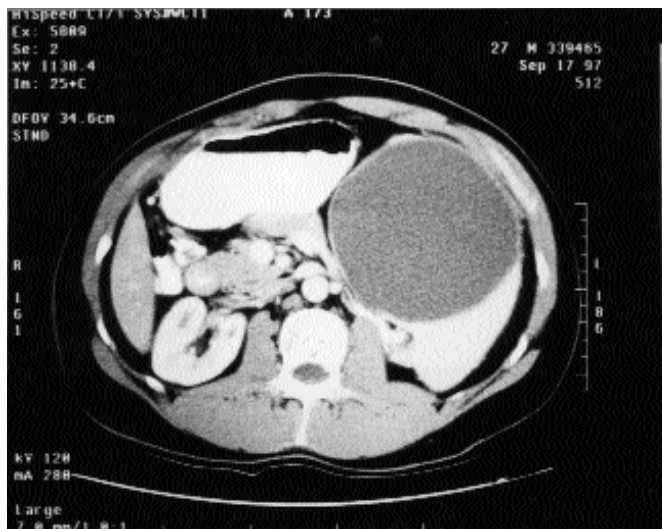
CT scan showing large splenic cyst.
